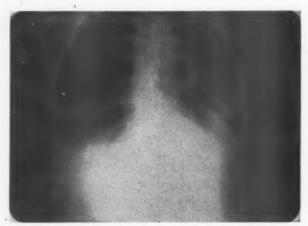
Roentgenogram of chest following the second pericardiocentesis demonstrating an air-fluid level in the pericardial sac.
